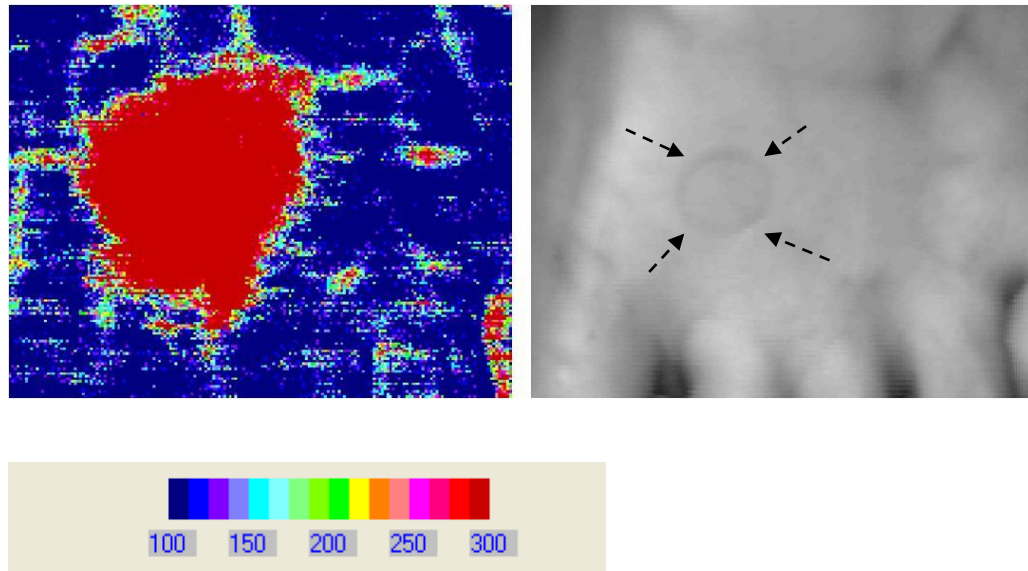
The post stimulation (skin heating) laser Doppler image acquired using a LDI.
